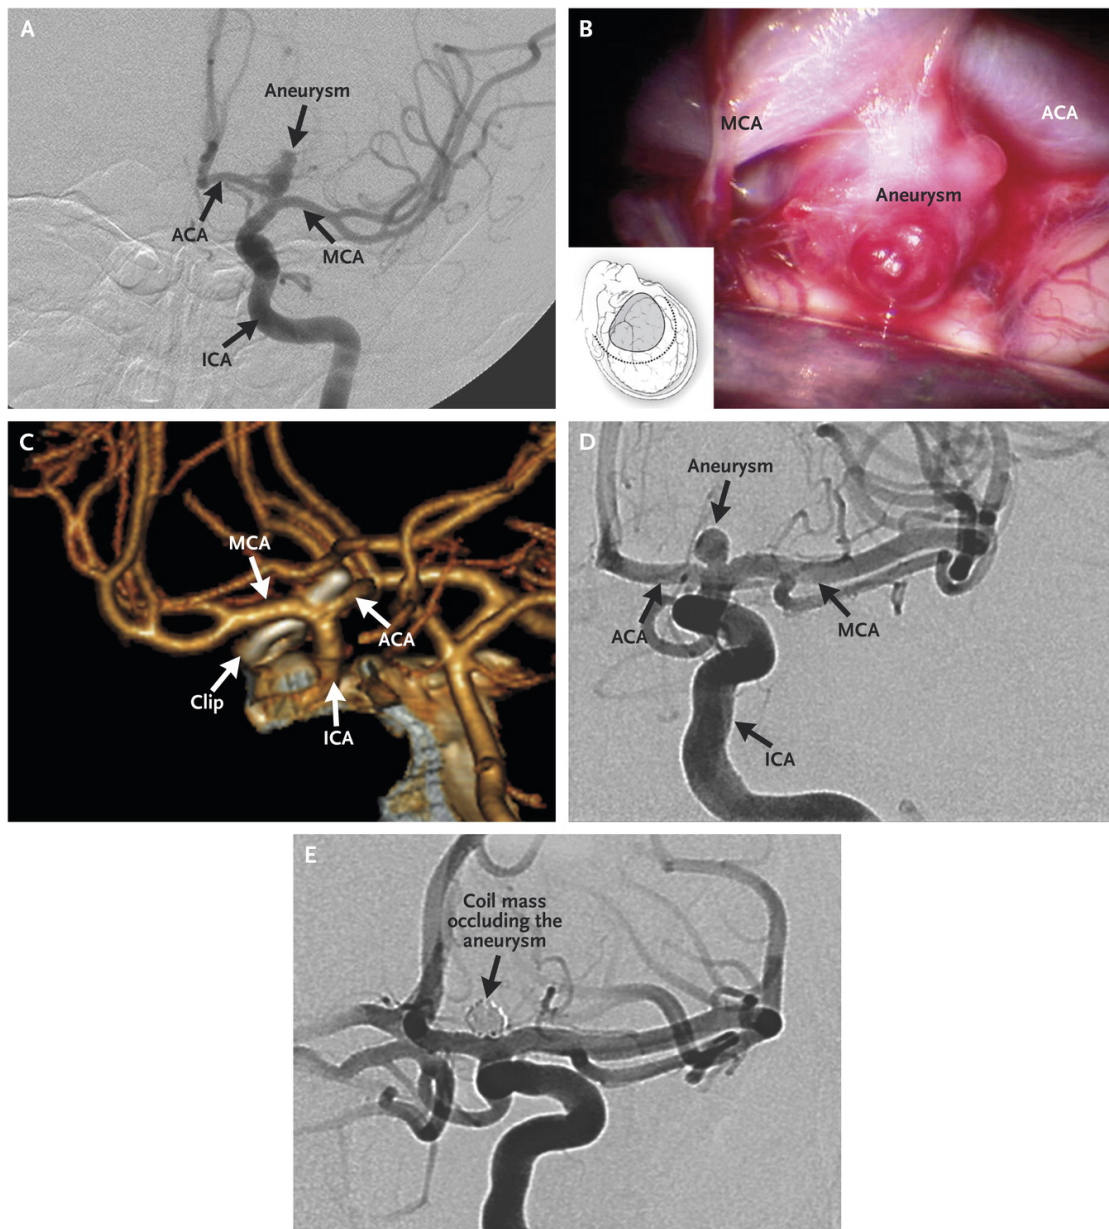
Angiogram showing internal carotid artery (ICA) aneurysms before and after treatment. The aneurysm originates at the point where the ICA bifurcates into the arterial cerebral artery (ACA) and the middle cerebral artery (MCA) (Panel A). At the time of surgery, the aneurysm was exposed and was shown to be multilobulated, very thin-walled, and with friable daughter lobules (Panel B; the inset shows the location of the aneurysm in the patient's brain). CT angiography shows the placement of a surgical clip and complete obliteration of the aneurysm (Panel C). An angiogram obtained in a different patient shows a similarly located ICA aneurysm (Panel D) and the results obtained with endovascular treatment (Panel E). Reproduced with permission from Lawton MT, Vates GE: Subarachnoid Hemorrhage. *N Engl J Med* 377:257–266, 2017. Copyright Massachusetts Medical Society.
